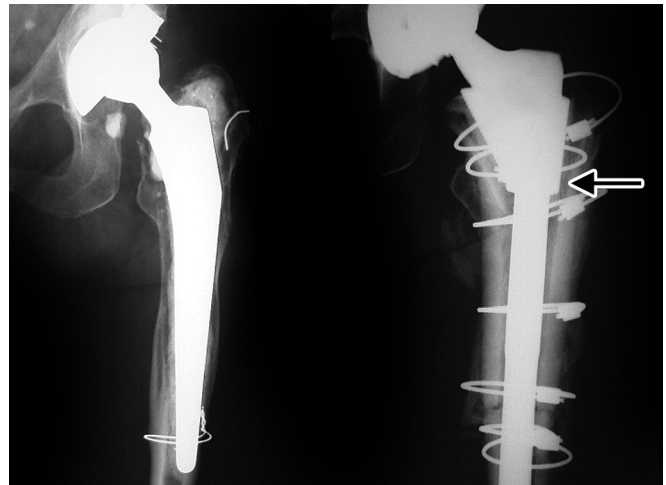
Arrow shows proximal femoral allograft reconstruction for 3C defect. Pre- and postoperative X-rays.
